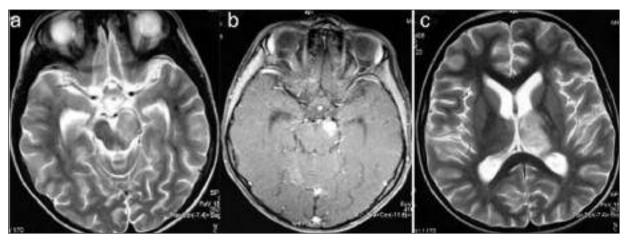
Repeated MR images at day 45. Axial T2 weighted (a), postcontrast T1 weighted (b) images obtained at the same level and axial T2 weighted image from the basal ganglia (c) shows newly developed increased signal intensity at the optic chiasm, left thalamus and left cerebral peduncle. The left cerebral peduncle is enlarged and shows nodular enhancement. Please note that the right thalamus is normal at this stage.
